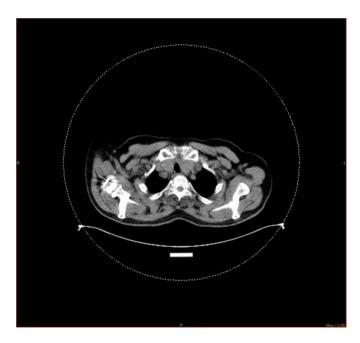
Axial CT scan at the level of the lung apices shows a calcification at the location of the radiotracer uptake.
